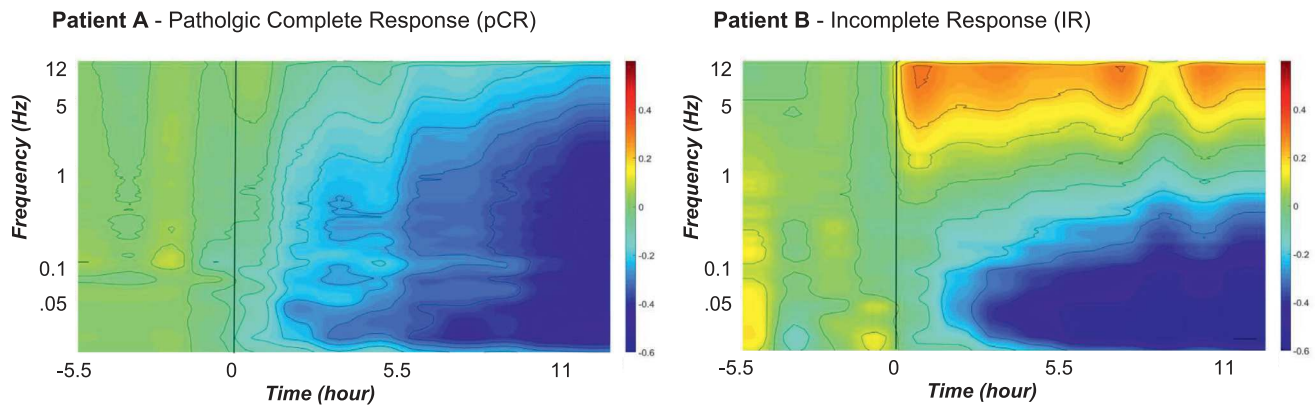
Biodynamic time-frequency spectrograms. Ex vivo response to GEMCIS treatment for tumor biopsies from 2 patients: Patient A achieved pathologic complete response (pCR) vs. Patient B who had an incomplete response (IR). The horizontal axis follows the 18-hour time course of the biodynamic profiling test, and the vertical axis is the Doppler frequency associated with intracellular motions. The 5.5-hour baseline period is followed by application of the GEMCIS treatment at time $t=0$ and 12.5 hours of drug-response monitoring. The vertical color scale is from -0.6 to +0.6 representing the fractional change in Doppler spectral density. Positive (red) values indicate enhanced kinetic activity, and negative (blue) values suppressed kinetic activity. Patient A shows broad motion suppression across all frequencies in response to the drug, which correlates with tumor cell death. In contrast, patient B exhibits strong high-frequency enhancement, indicative of decreased pharmacologic effect.
